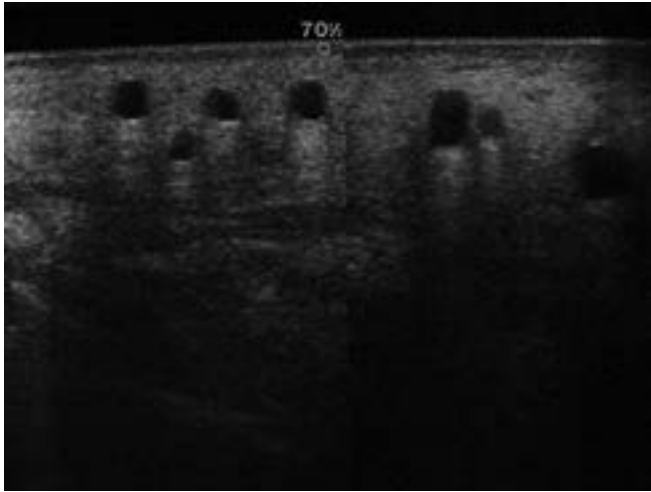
Breast ultrasound determinate several cysts of multiples sizes in all the breast tissue.
